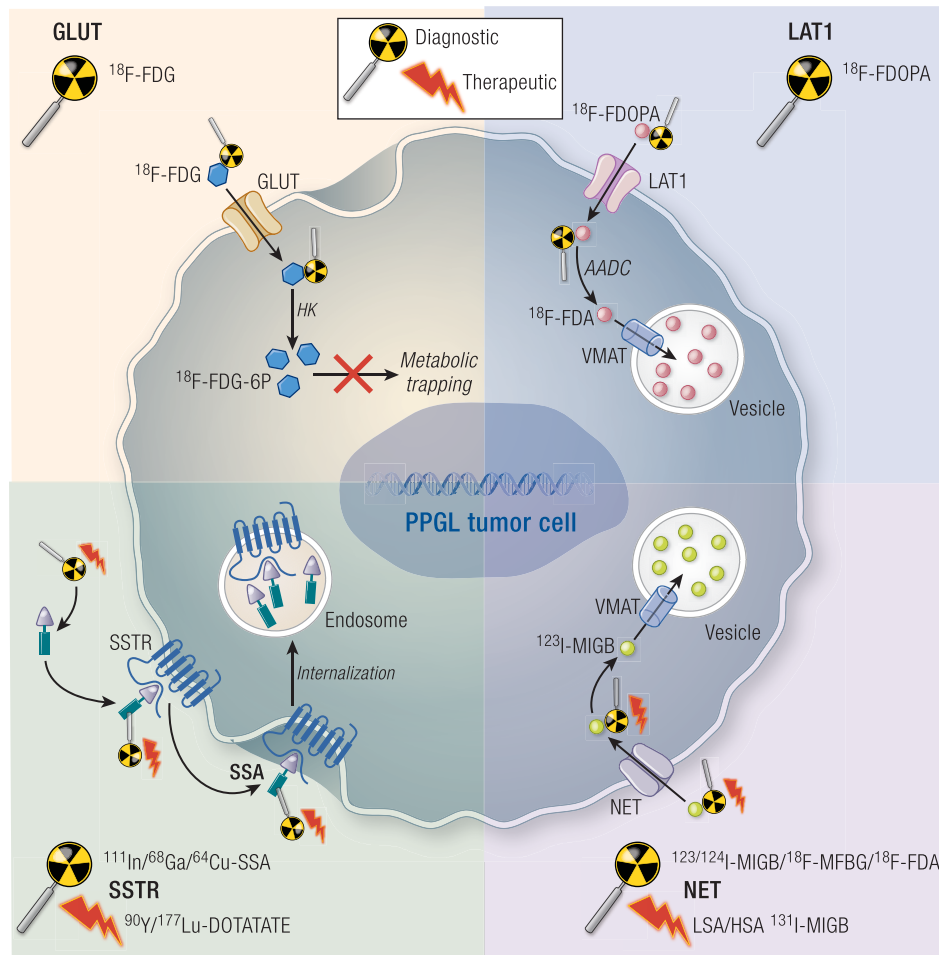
Radionuclide targets in PPGL. Functional imaging and theranostics of PPGL relies on radionuclide targeting of transporter systems and receptors on the tumor cell membrane. These targets include the glucose transporter (left upper panel), L-amino acid transporter 1 (right upper panel), the NET (right lower panel), and the somatostatin receptor (left lower panel). After entry into the cell through transporters, radionuclides are either metabolized and trapped (^{18}F -FDG, left upper panel) or stored in catecholamine vesicles either directly (eg, ^{123}I -MIBG, right lower panel) or after metabolization (^{18}F -FDOPA, right upper panel). Alternatively, somatostatin analogue radionuclides bind to their receptor(s) and are subsequently internalized (left lower panel). Abbreviations: AADC, aromatic amino acid decarboxylase; FDA, fluorodopamine; FDG(-6P), fluorodeoxyglucose (-6 phosphate); FDOPA, fluorodihydroxyphenylalanine; GLUTs, glucose transporters; HK, hexokinase; LAT1, L-amino acid transporter 1; MFBG, meta-fluorobenzylguanidine; MIBG, metaiodobenzylguanidine; NET, norepinephrine transporter; PPGL, pheochromocytoma/paraganglioma; SSA, somatostatin analogue; SSTR, somatostatin receptor; VMAT, vesicular monoamine transporter.
